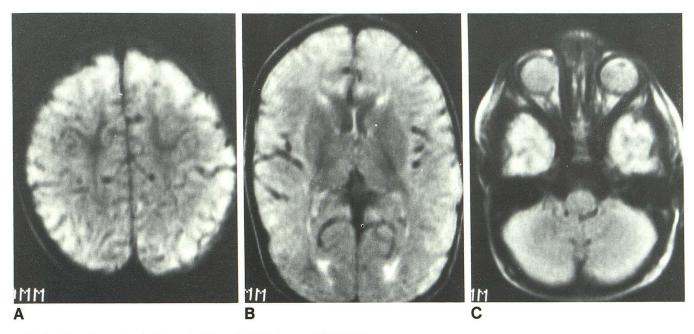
Transition pattern in 11-month-old boy. Axial MR images (SE 2000/84).
